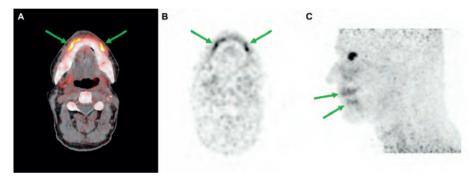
Case C. Transverse slice of fused PET/CT (A), PSMA PET (B), and lateral maximum intensity projection of PSMA PET with indication of prior radiotherapy field in red (C). Complete loss of PSMA uptake is seen in most salivary glands after radiotherapy. Remarkably, PSMA PET indicates hypertrophy of the spared minor salivary glands in the lips (green arrows).
